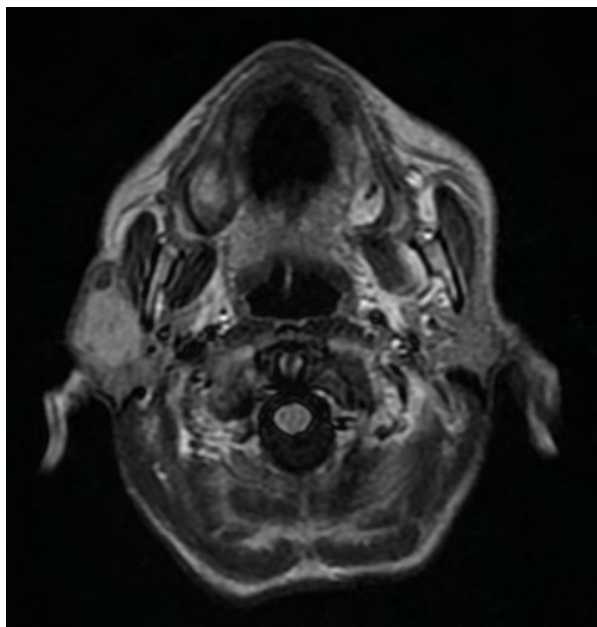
Brain MRI. Tumour of right salivary gland
